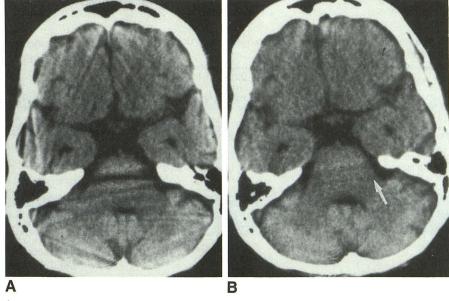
A and B, Noncontrast axial CT images obtained with conventional 5-mm scan (A) and two contiguous 2-mm sections that have been averaged (B). Streak artifact in temporal fossa is virtually eliminated.
